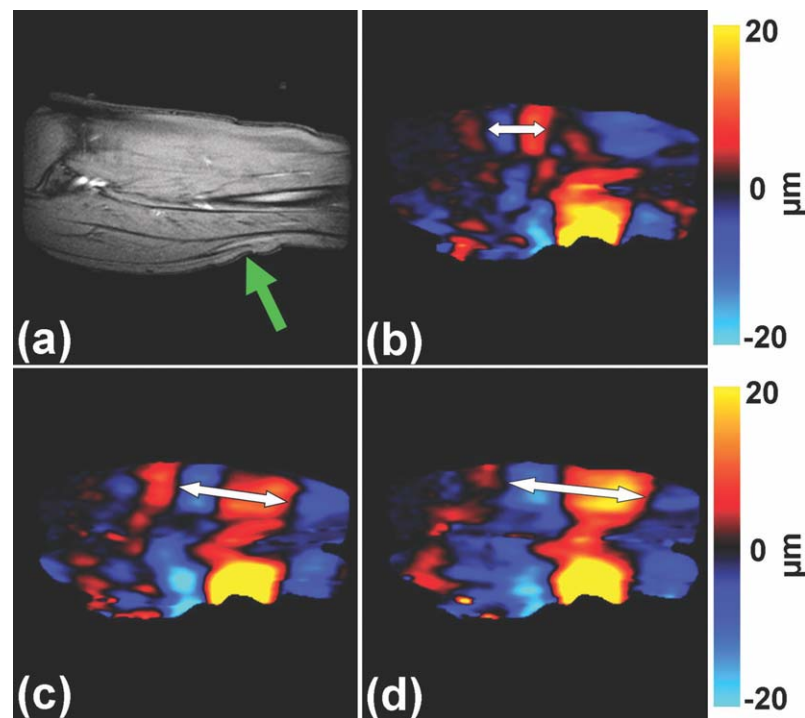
Skeletal muscle MRE. a: A sagittal MR image of the calf soleus muscle with the location of the driver indicated by the arrow is shown. 100-Hz MRE wave images of the muscle are shown while exerting 0 (b), 5
